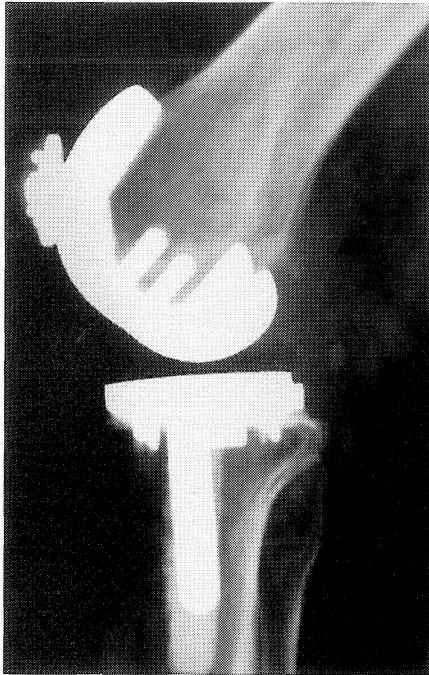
Three years postoperatively a lateral radiograph showed no evidence of posterior subluxation. Clinically the patient had a stable, painless knee.
